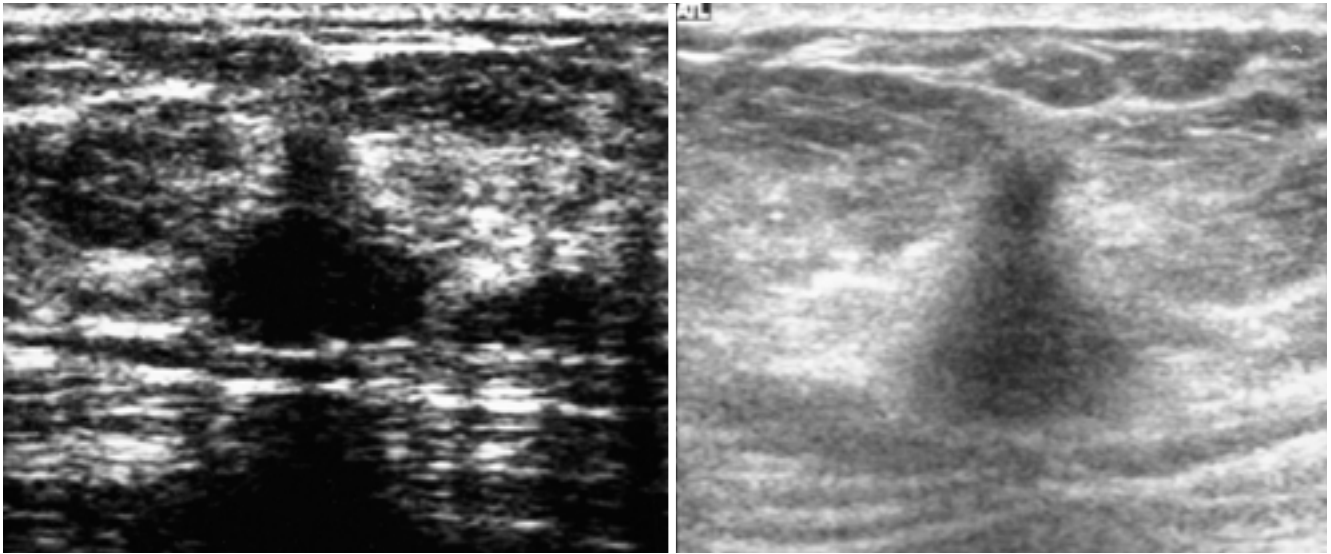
Transverse sonogram of the breast obtained with convex probe.
